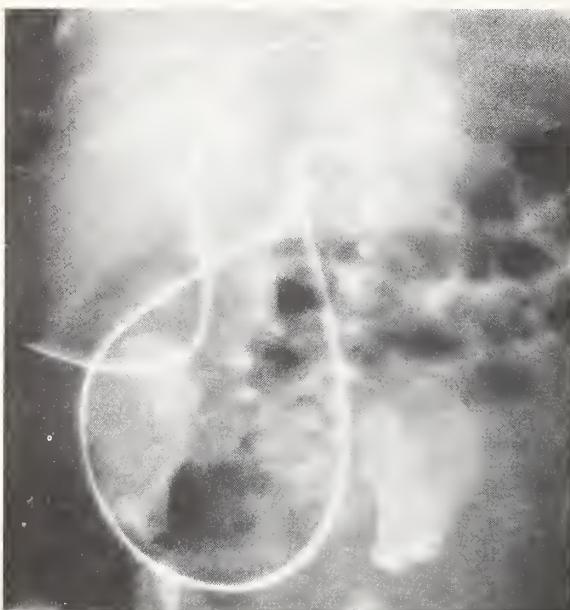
An umbilical venous catheter utilized for an intravenous pyelogram. On the first roentgenogram after the injection of contrast there is opacification of hepatic lobules.
